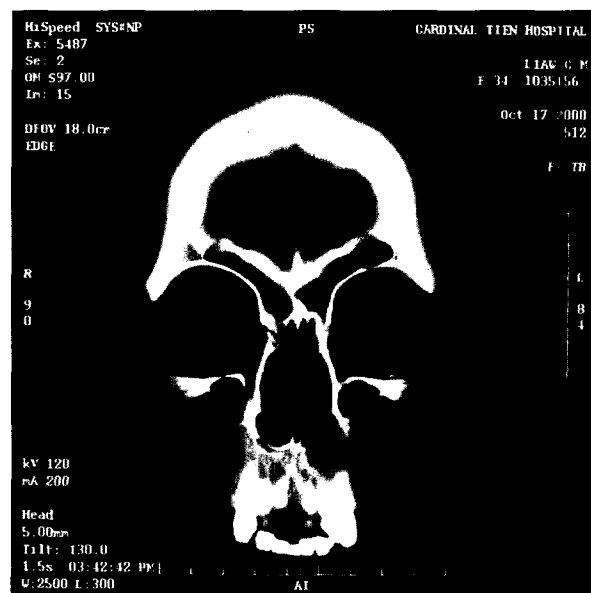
Preoperative sinus computed tomography images of a 34-year-old woman showing a nasolabial cyst over the left premaxillary area.
